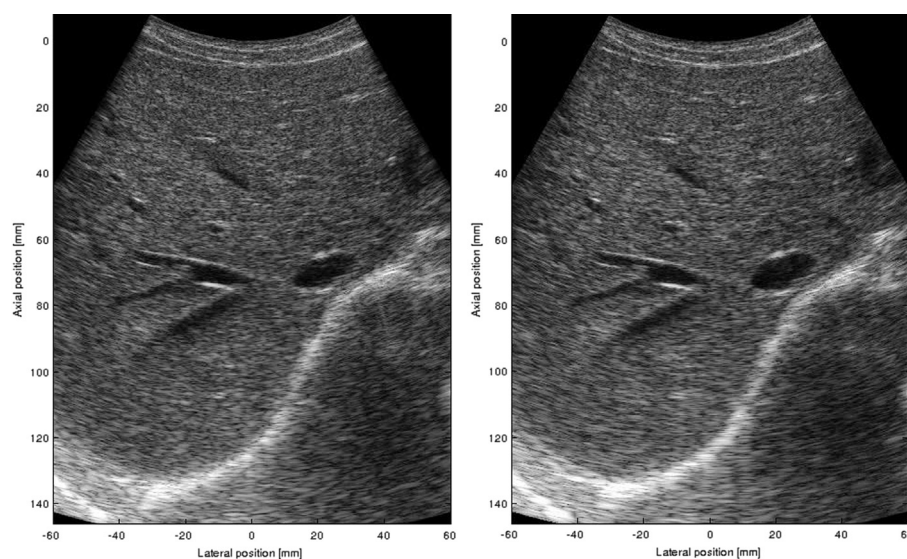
Recording of healthy liver tissue with liver veins. The images are the interleaved recordings, with synthetic aperture sequential beamforming on the left and conventional ultrasound on the right.
